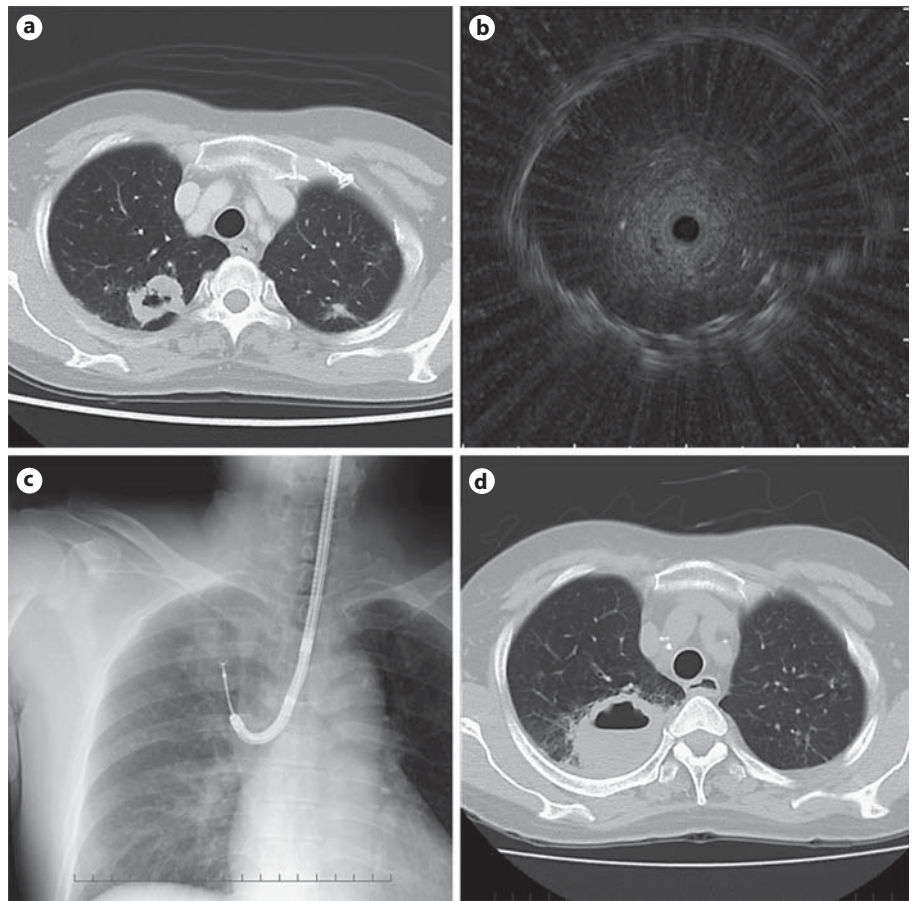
A 64-year-old female who developed lung abscess after EBUS-GS. a A 32-mm mass with cavity in the right S1. b The radial probe could be located within the mass. c X-ray fluoroscopic image of EBUS-GS TBB. d Chest CT on day 9 after admission showed an increase in size and appearance of air-fluid level and consolidation.
